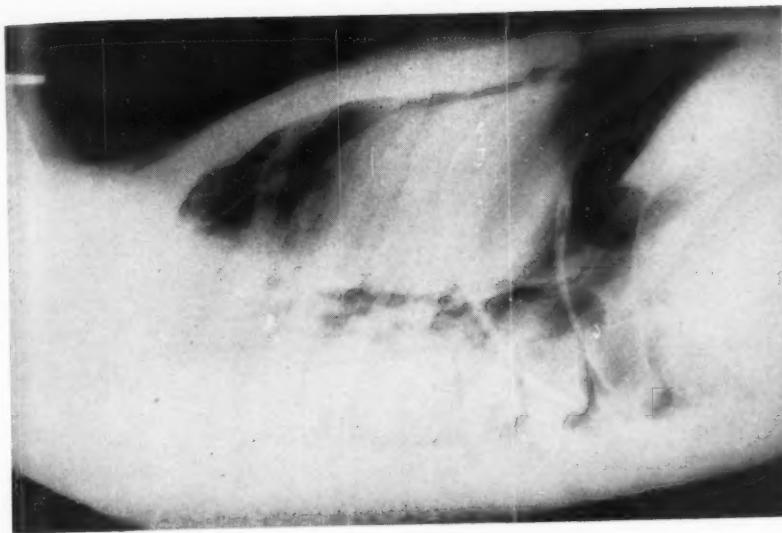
Lateral X-ray showing a column of air separating the heart from the mediastinum.
